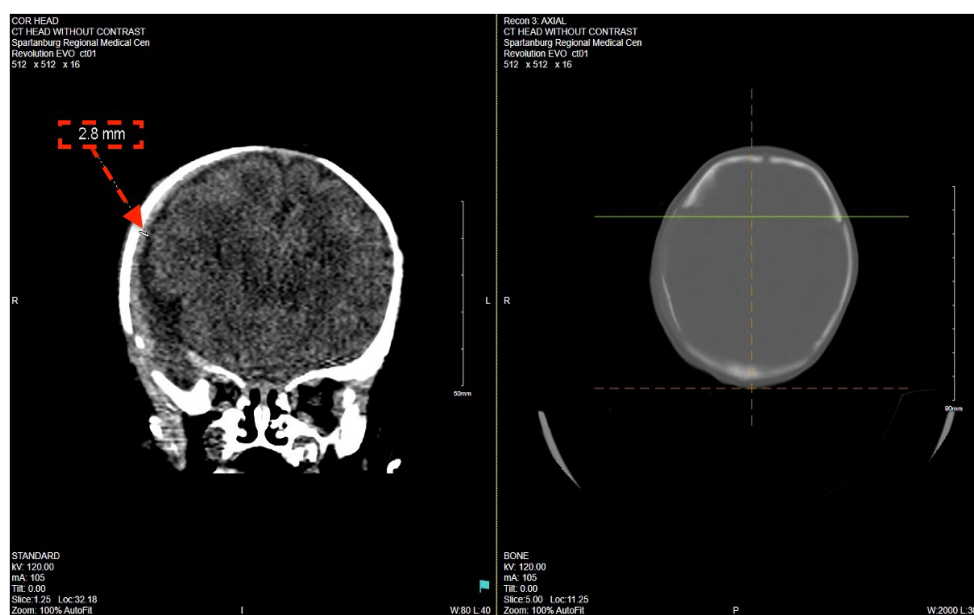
CT revealing subdural hematoma.
